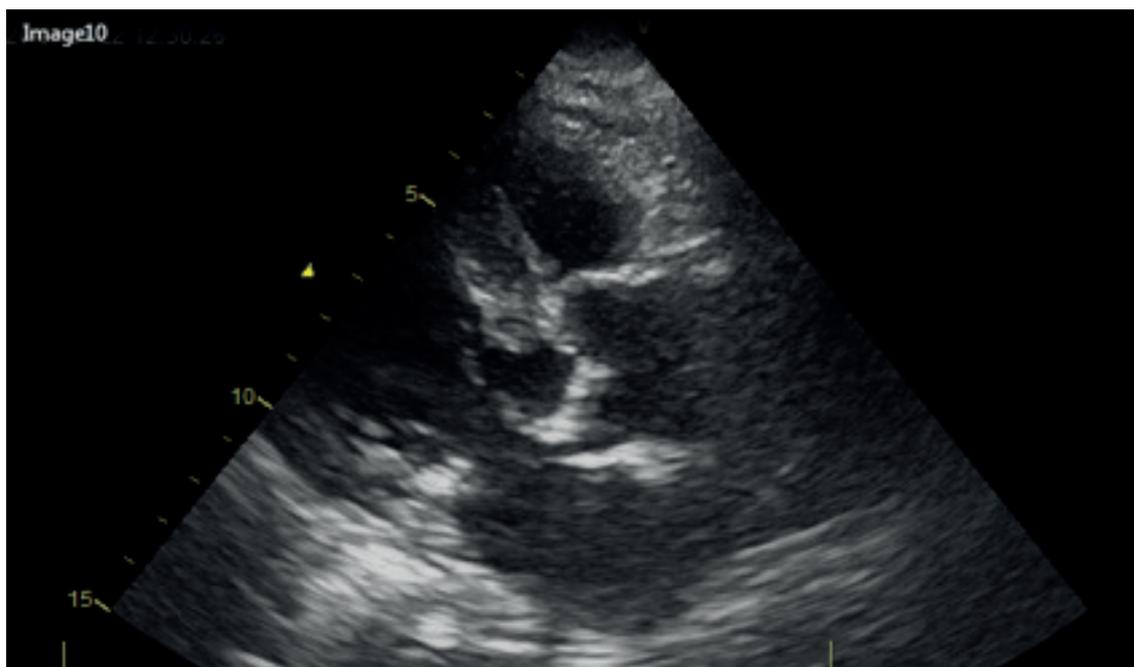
Transthoracic echocardiography image,septal hypertrophy.
